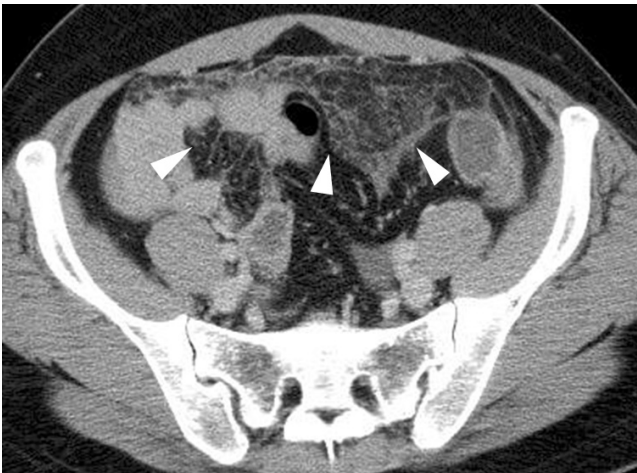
27-year-old woman with pelvic inflammatory disease. CT scan shows diffusely increased mesenteric fatty infiltration (arrowheads) in pelvic cavity.
